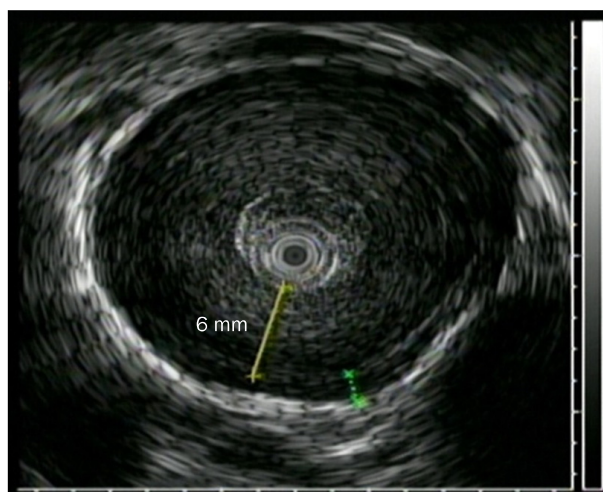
The initial endoscopic ultrasonography. Esophageal inner circular muscle is thickened by 6 mm at mid to lower esophagus level.
